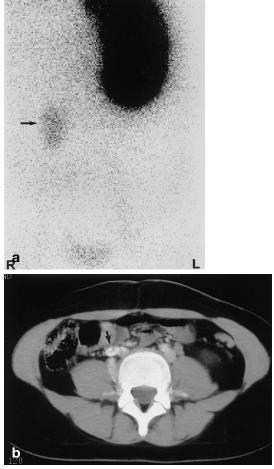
Poorly functioning single system kidney and absence of ureteral orifice in the bladder mistaken for renal agenesis. This girl was diagnosed shortly after birth as having left-sided primary megaureter on EU that was done for evaluation of urosepsis. The right kidney was not seen. There was no right ureteral orifice at cystocopy and right renal agenesis was diagnosed. This incorrect deduction led her physicians to misinterpret her many years of constant day and night wetness. She underwent pharmacologic treatment, perineal exercises, and behavior modification until the age of 8 years 2 months when, in desperation, she was referred to a pediatric urologist. A Tc-99m-dimercaptosuccinic acid (DMSA) scan (a) and an enhanced CT scan (b) demonstrated the small, poorly functioning dysplastic ectopic right kidney (arrows) that had a single collecting system draining into the vagina. This kidney was resected; postoperatively, she was dry after a lifetime of wetting
